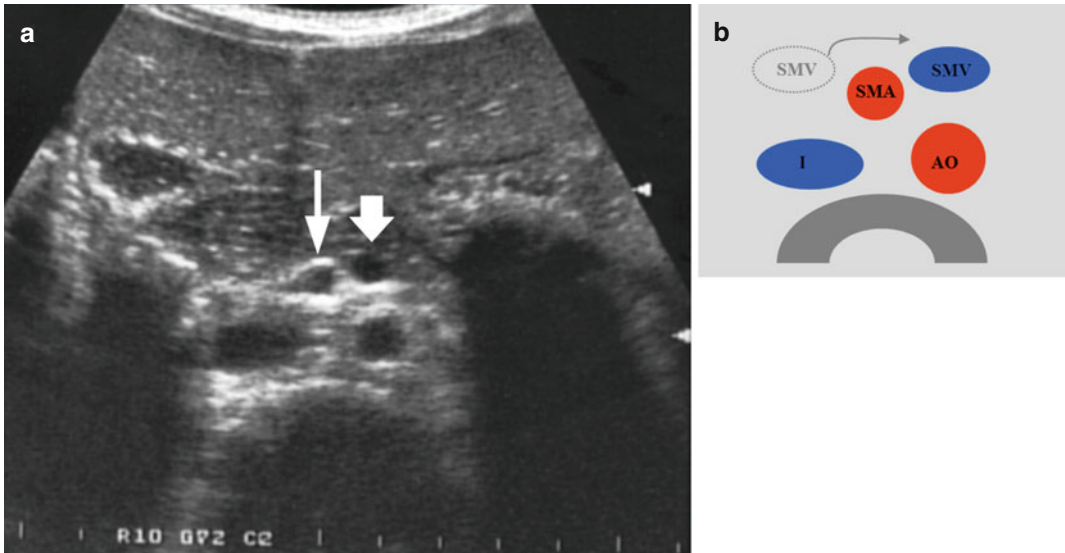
(a) Sonogram showing inverted position of mesenteric vessels in malrotation. The superior mesenteric vein (*thick arrow*) is positioned to the left of the superior mesenteric artery (*thin arrow*) on an axial plane.
